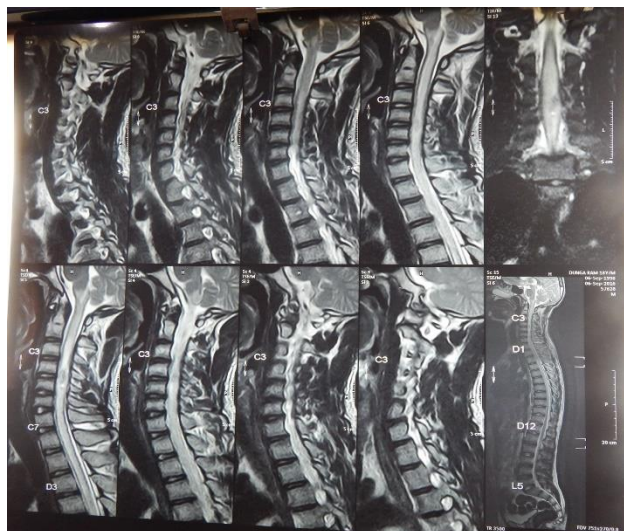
MRI cervical spine showing intramedullary mass.
